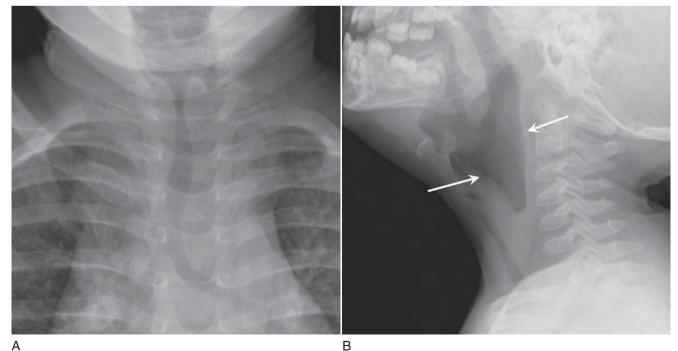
Croup: 16-month-old boy with stridor. Frontal radiograph (A) demonstrates smooth symmetrical narrowing of the subglottic airway. Lateral view (B) also demonstrates diffuse narrowing of the subglottic airway as well as ballooning of the hypopharynx (*arrows*).
